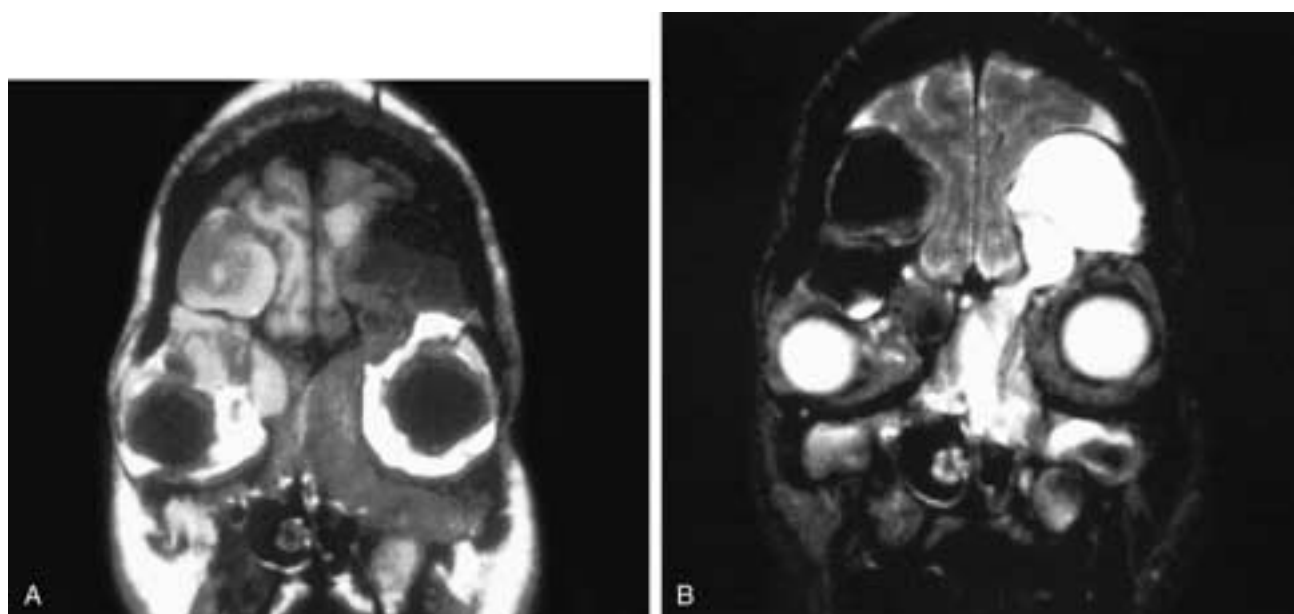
Coronal T1-weighted (A) and T2-weighted (B) MR images show bilateral sinonasal polypoid masses that have broken intracranially, into the left superomedial orbit from the left frontal sinus, and down into the right superior orbit from a right supraorbital ethmoid cell. The signal intensities of the left-sided lesions are those of classical inflammation. The right-sided lesions contain thicker inspissated secretions and have intermediate T1-weighted and low T2-weighted signal intensities. This patient has polyposis.
